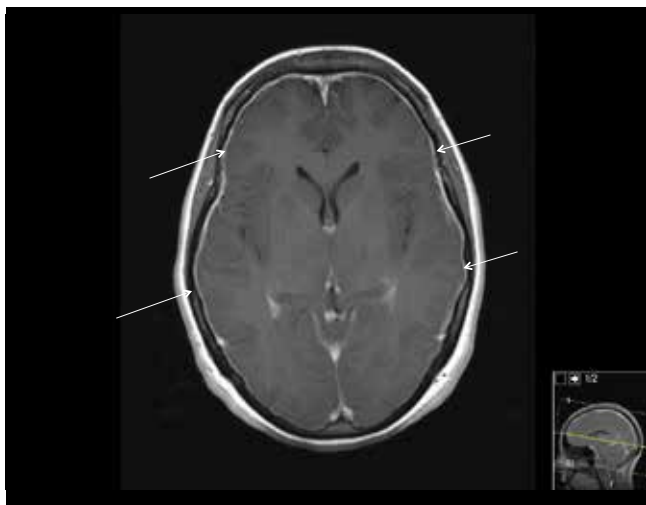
Gadolinium enhanced MRI showing marked dural enhancement (arrows). Symptoms were abolished following 2 epidural blood patch procedures.
